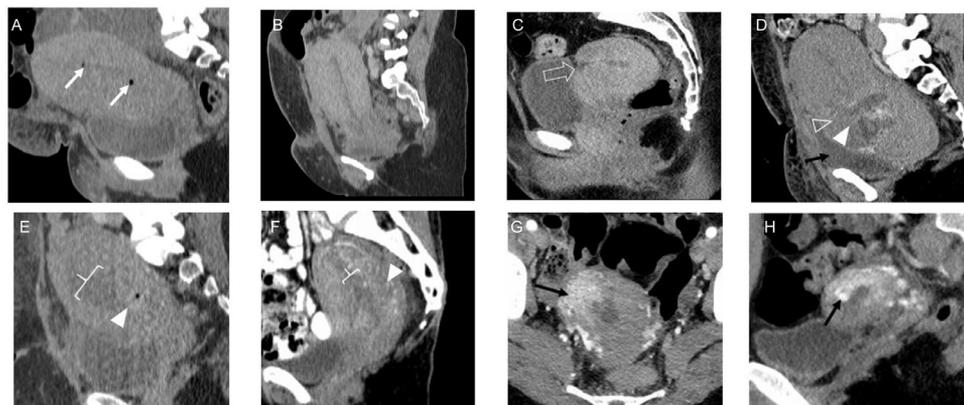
Postpartum imaging of the pelvis can identify complication of pregnancies. (A) sagittal CT image during postpartum hemorrhage evaluation shows small flecks of gas (arrows), a normal finding. (B) sagittal CT image of the pelvis shows a normally enlarged postpartum uterus with a thin endometrial canal. (C) sagittal CT image shows thinning of the lower uterine segment (open arrow) at the site of prior cesarean section which can place the patient at risk for uterine rupture with subsequent pregnancies. (D) sagittal CT image shows a heterogeneous fluid collection (open arrowhead) at the site of cesarean section, with fluid (black arrow) anterior to the uterus in the setting of acute postoperative hemorrhage after cesarean section. (E) sagittal CT image shows a fluid filled endometrial canal (bracket) with a discrete soft tissue nodule and gas (arrowhead), in the setting of retained products of conception and endometritis. (F) sagittal CT image shows a fluid filled endometrial canal (bracket) with a focal area of high attenuation (arrowhead) which was clotted blood in the setting of postpartum hemorrhage. (G) and (H) coronal and sagittal CT images of arteriovenous fistula (black arrows) in the uterus after elective abortion.
